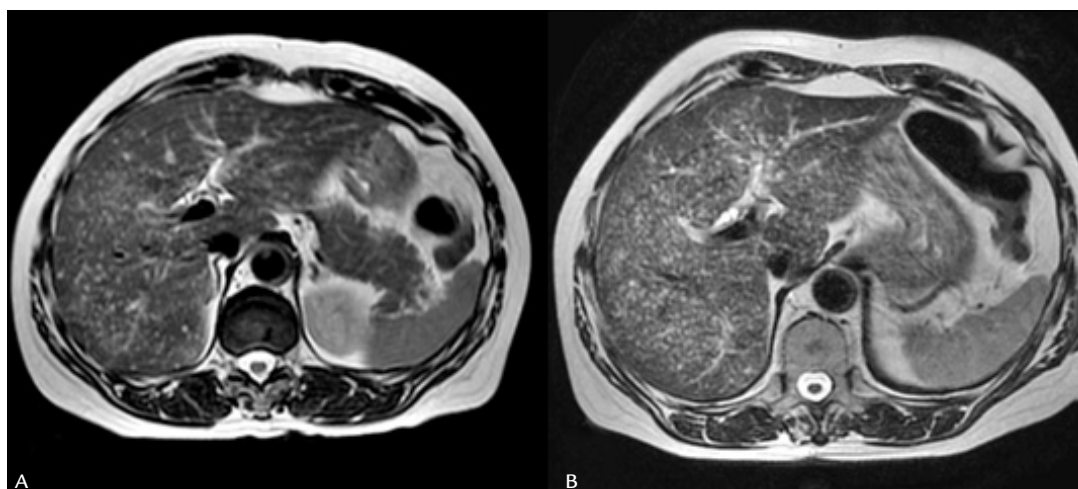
Axial T2-weighted MRI: multiple nodular hyperintense lesions that progressed along the three years of follow-up: 2010 (panel A) to 2013 (panel B).
